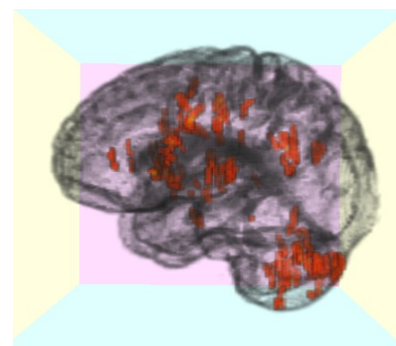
Figure MRI Infarct distribution.
